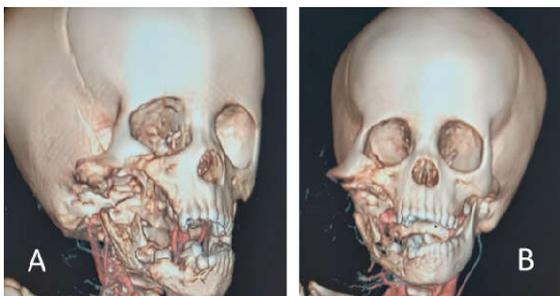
CT with 3D reconstruction showing an osteolytic mass of the right maxilla with involvement of the mandible (squamous cell carcinoma)
